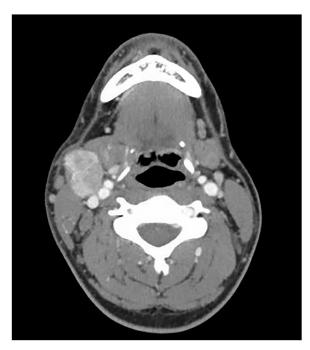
Axial cut of a computed tomographic scan with contrast of an 8-year-old girl with papillary thyroid carcinoma. The 3 × 4-cm lymph node superficial to the great vessels in the right neck represents a regional metastasis of the disease.
